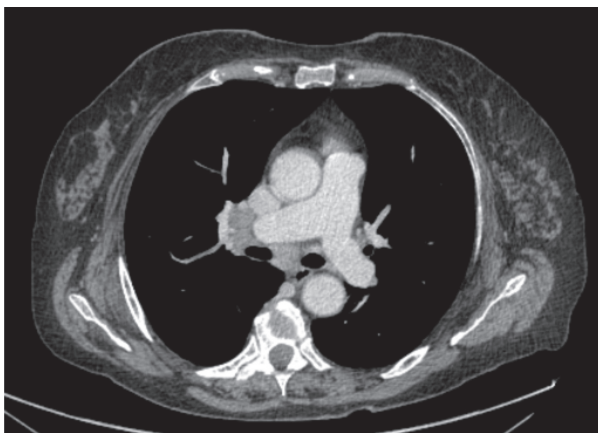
Second case: total body CT showing the increased volume of hilar and mediastinal lymph nodes
